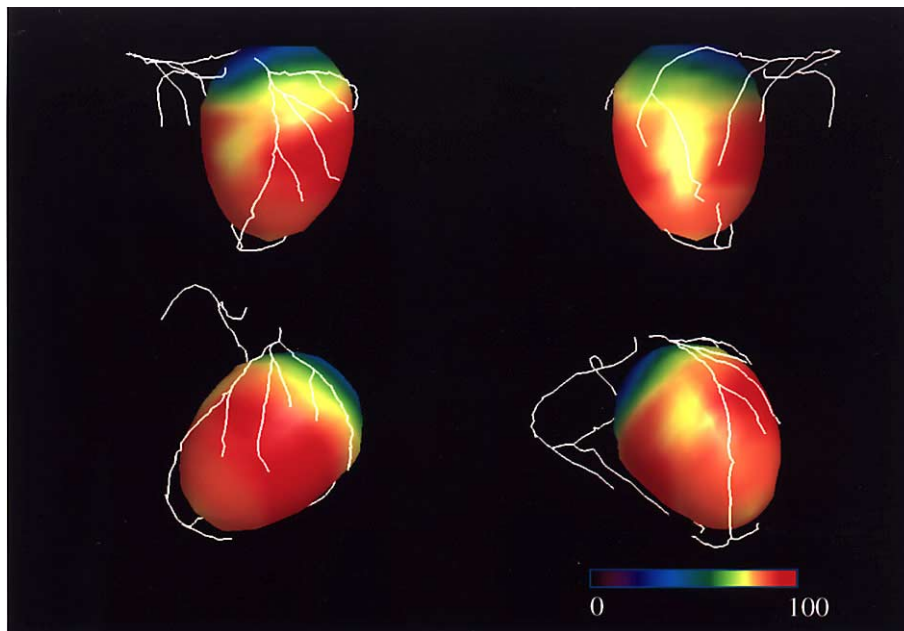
An example of the final 3D registration and fusion images of SPECT and CTCA are displayed (*top left*; anterior view, *top right*; inferior view, *bottom left*; LAO view, *bottom right*; RAO view).
